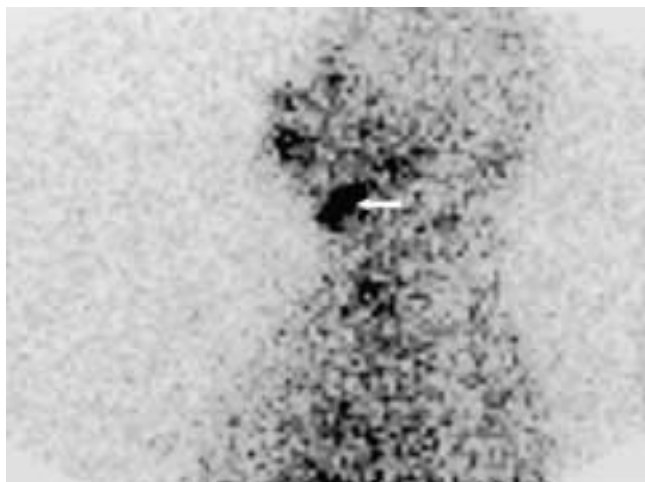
Lingual thyroid. Lateral I-123 scintigraphy showing increased radiotracer uptake at the base of the tongue region consistent with lingual thyroid (*arrow*). (Courtesy of Dr. Joseph Sam, Department of Radiology, Nuclear Medicine Division, University of Pennsylvania Medical Center.)
